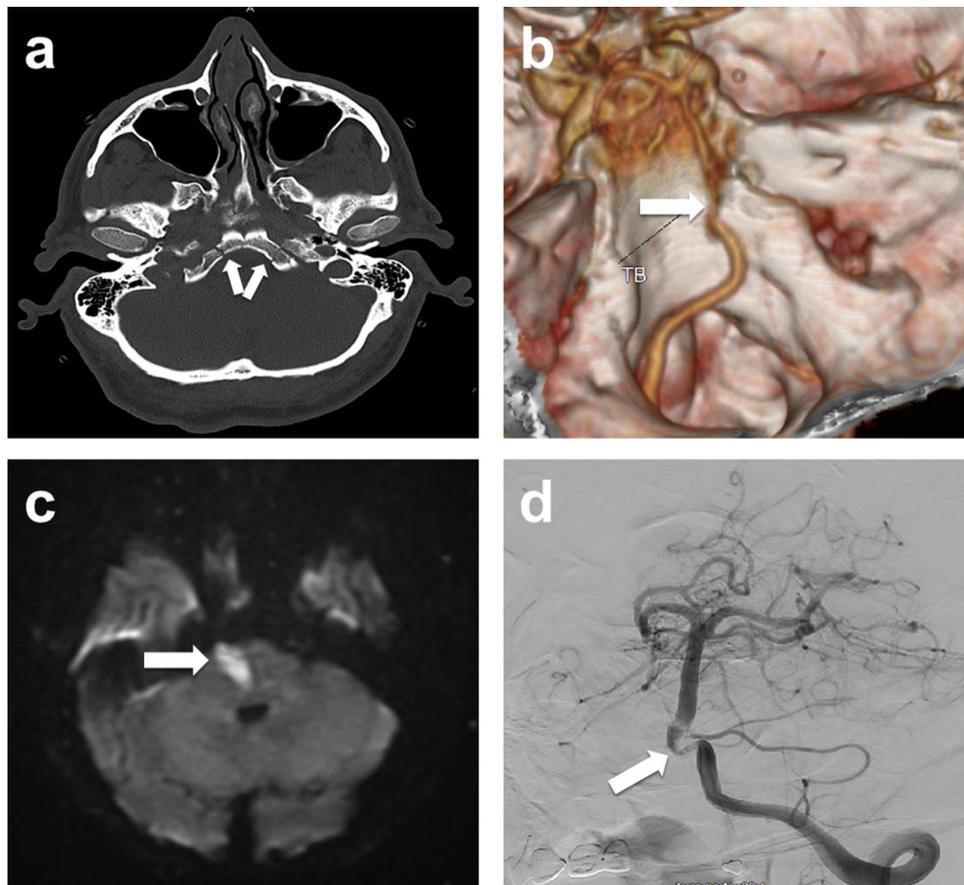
Description of a basilar artery entrapment in a clivus fracture. (a): this bone window skull CT scan demonstrates a longitudinal clival fracture (Arrow); (b): the 3D CT angiogram reveals a narrowed BA which is incarcerated within the clivus fracture (Arrow); (c): MRI in diffusion sequence shows an infarction in the central and right pons (Arrow); (d): DSA of the VA-BA reveals a dissection of the BA caused by the entrapment (Arrow).
